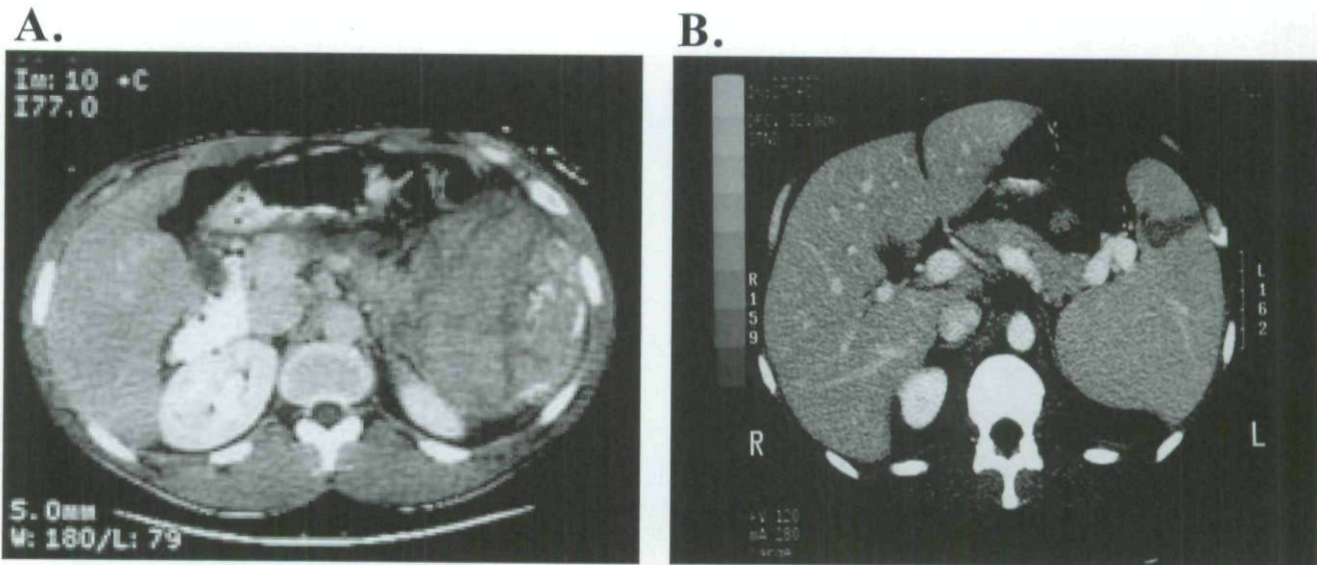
Splenic rupture in the setting of HIV infection. The spleen undergoes pathologic changes in the setting of HIV infection. In this HIV-positive patient, a significant splenic injury was incurred after a motor vehicle accident. The splenic injury (A) was managed nonoperatively and a computed tomography scan 1 month after the injury reveals nearly complete healing.
